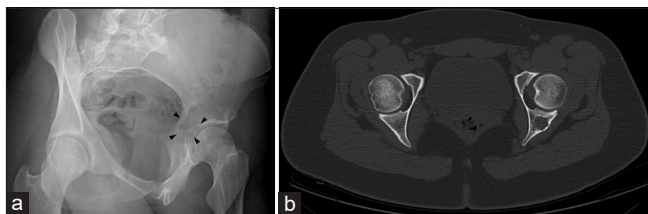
An 18-year-old female with low-grade chondrosarcoma discovered incidentally on computed tomography during evaluation of unrelated gastrointestinal symptoms. (a) XR of the left posterior oblique pelvis shows radiolucency along the posterior margin of the acetabulum. (arrowheads) (b) Pelvic CT shows lytic lesion with endosteal scalloping of the acetabulum, respectively.
